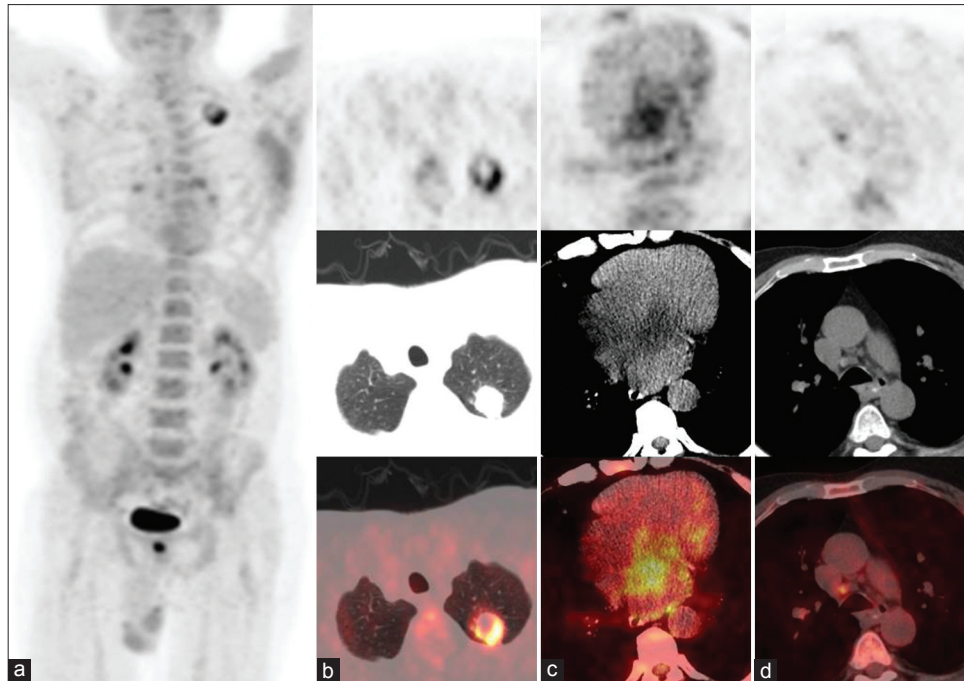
Although intense hypermetabolism was seen in the lung nodule (standardized uptake value [SUV]max = 10.3) (a: Maximum intensity projection image, b: axial PET, CT and fusion PET/CT images from top to bottom), the lesion in the left atrium showed only mild to moderate heterogeneous FDG uptake (SUVmax = 4.2) (c). Mild hypermetabolic lymph nodes (SUVmax = 3.5) were also detected in the mediastinum (d)
